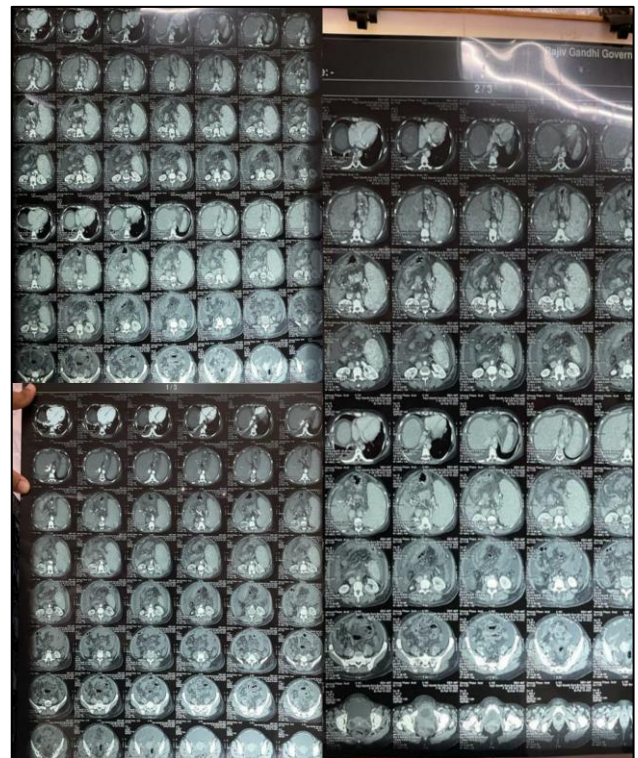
CT angiogram showing thrombosis at superior mesenteric vein and portal vein confluence with splenomegaly and chronic liver disease changes.
